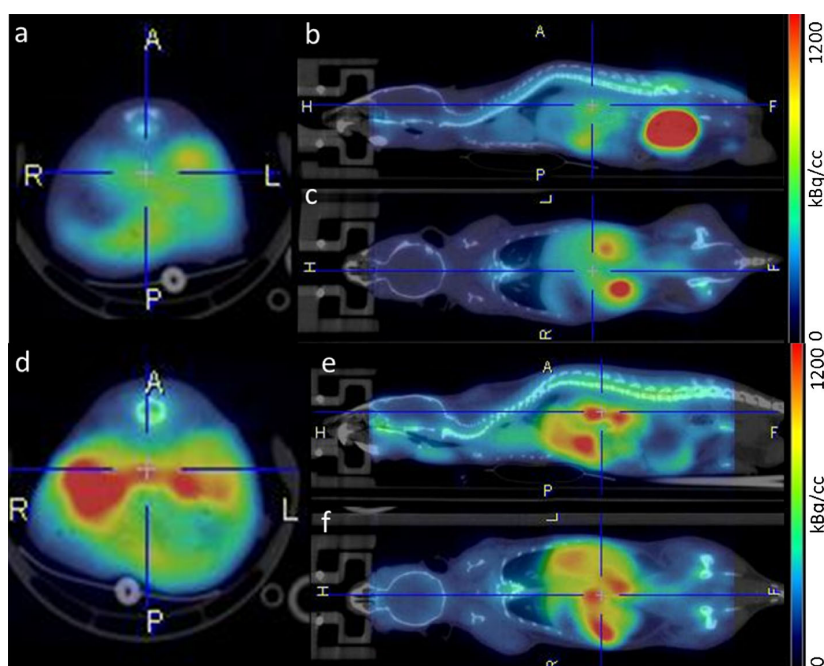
18 F-FDOPA PET/CT image: a transversal, b sagittal, c coronal image plane, and 18 F-FTYR PET/CT image: d transversal, e sagittal, f coronal image plane.
